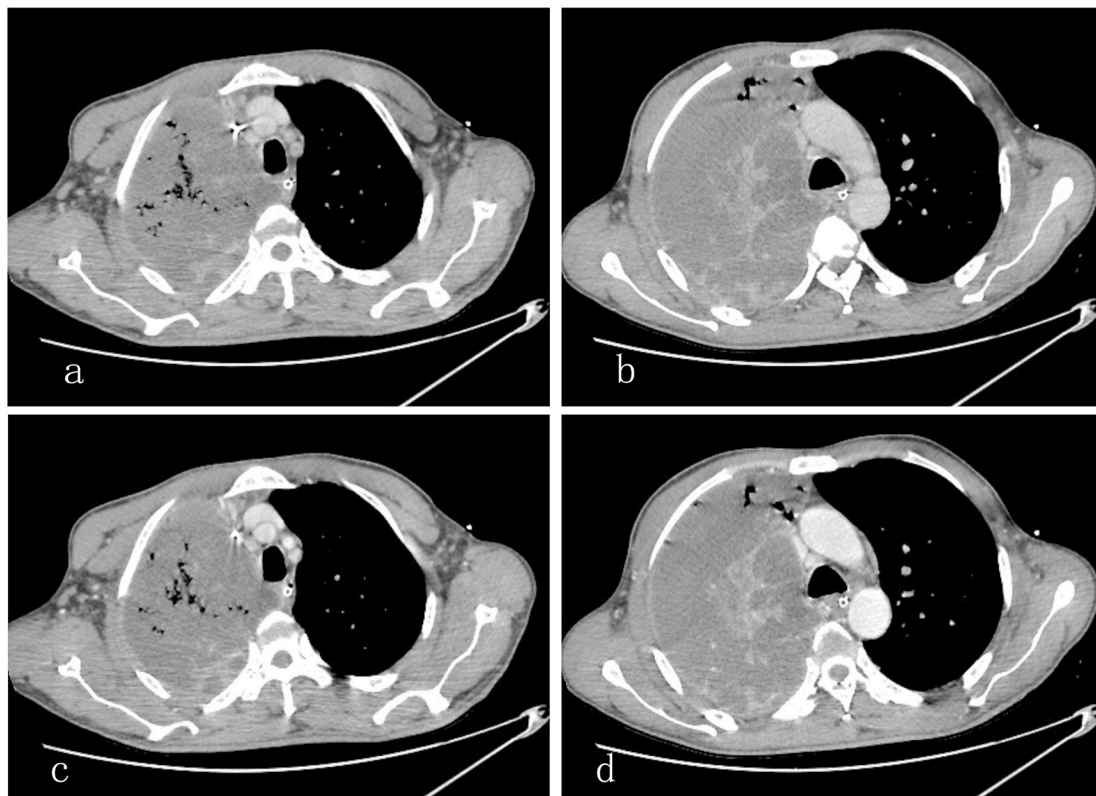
Thoracic CT scan showed lung consolidation in the right upper lobe with formation of abscess, (c) and (d) were during the hyper-enhanced phase.
